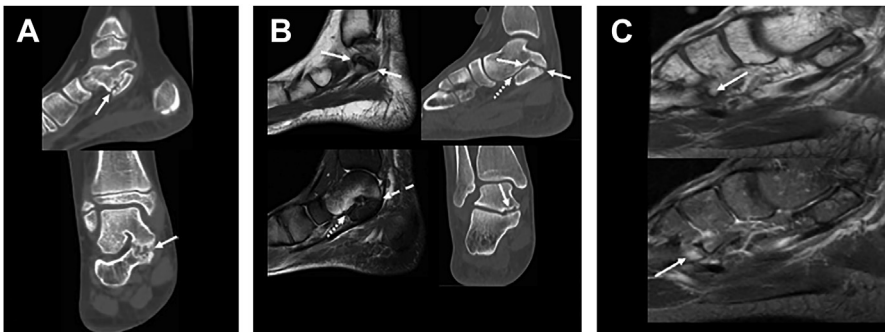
Tarsal coalition. (A) Ankle CT of a 9-year-old girl showing fibrocartilaginous talocalcaneal coalition at the middle subtalar joint, with irregularity of the apposed bone surfaces and subcortical cysts. (B) Ankle MRI and CT of an 18-year-old boy after an ankle sprain showing fibrocartilaginous extra-articular posteromedial coalition (arrow). Note the middle (dotted arrow) and posterior (dashed arrows) subtalar joints with the usual bone and chondral morphology. The areas of marrow edema have a contusional etiology. (C) Foot MRI of a 12-year-old boy showing partial plantar fibrocartilaginous coalition between the lateral cuneiform and the base of the third metatarsal, also with mechanical overload edema.
